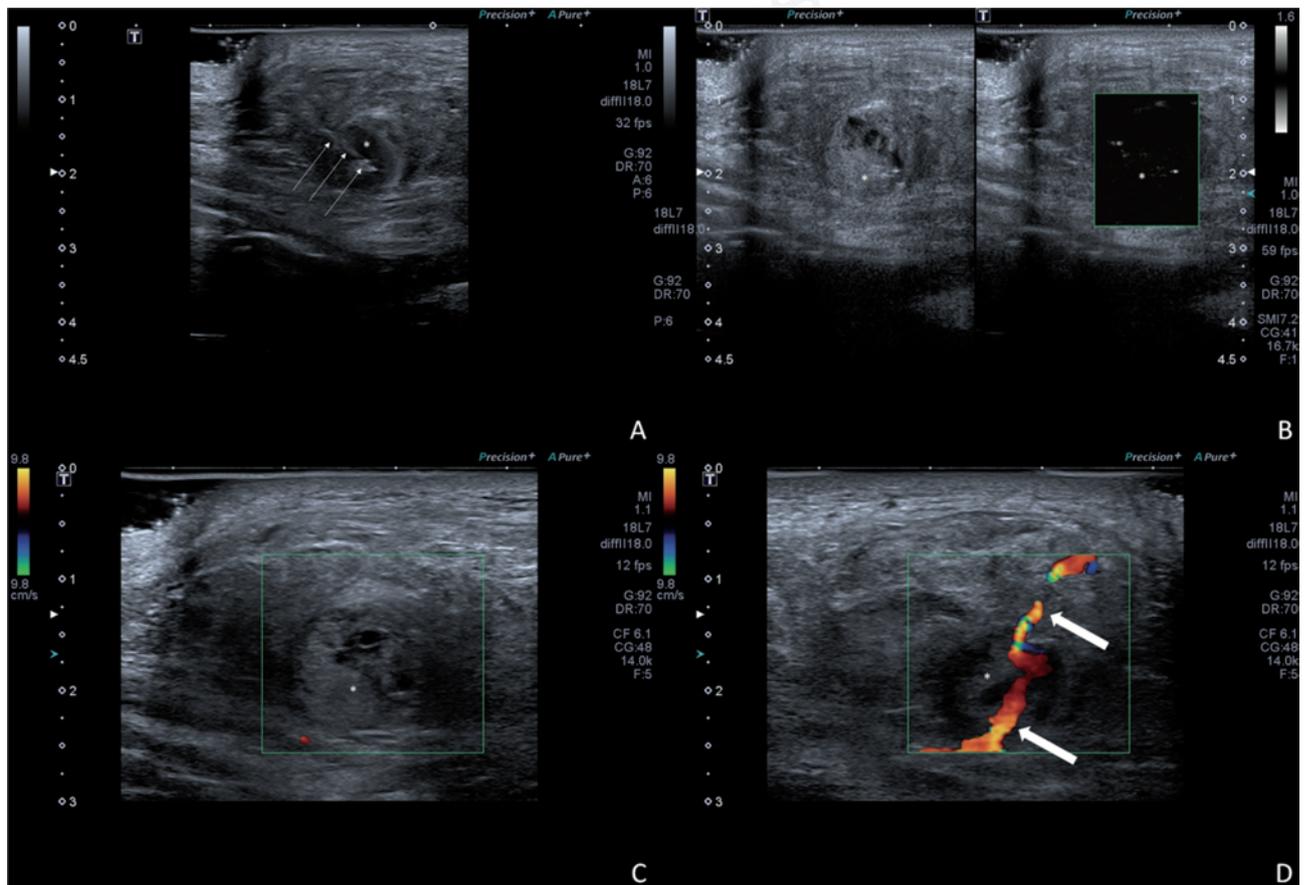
Ultrasound (US) guided percutaneous embolization of the pseudoaneurysm, with a 7-18 MHz linear probe (Aplio 500, Canon Medical Systems Corporation, Ōtawara, Tochigi, Japan). In image (A), a 22-gauge needle (thin arrows) is advanced in the pseudoaneurysm (*) and thrombin was injected in the sac. Subsequent controls with b-mode US (B, left-side), Superb Microvascular Imaging (SMI) (B, right-side), and color-Doppler US (C) demonstrates echostructured appearance of the pseudoaneurysm sac (*); neither SMI nor color-Doppler show any vascular signal within the sac (*). In image D, the preserved feeding vessel (thick arrows) can be seen adjoining the thrombosed the pseudoaneurysm sac (*).
